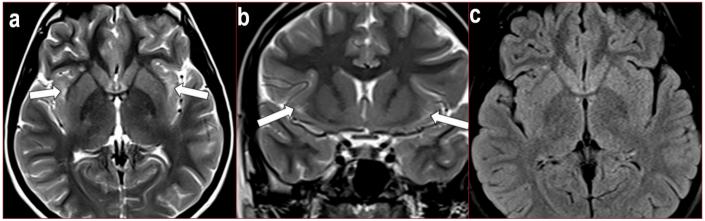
16-years-old girl complains of dizziness. Hyperintense TZM (arrows) is present in bilateral insular subcortical WM in transverse (a) and coronal T2WI (b). Transvers T2-FLAIR (c) show isointensity according to white matter in same section. (TZM: Terminal zones of myelination, WM: White matter)
